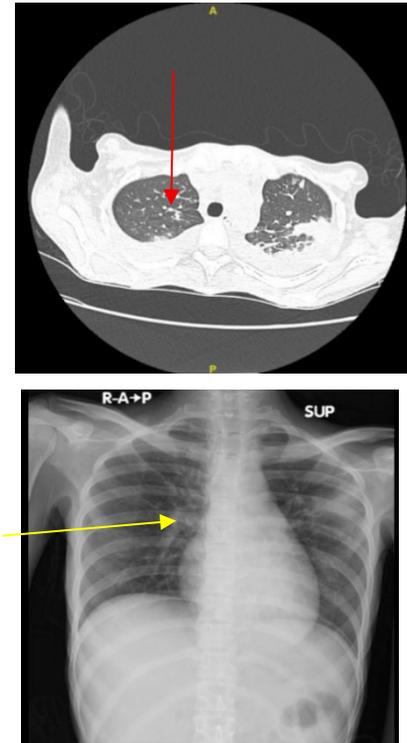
Chest X-ray showed left pulmonary fibroinfiltrate, suspected as pulmonary tuberculosis (yellow arrow), and subsequent computed tomography of chest revealed ground glass opacity with centrilobular nodules in bud, bilateral pleural effusion with compressive atelectasis (red arrow)
